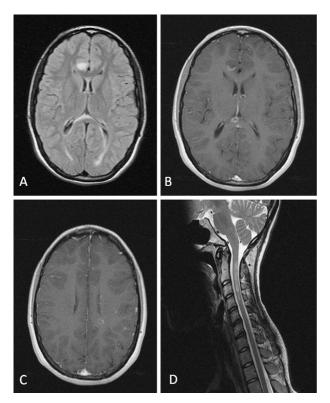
MRI images showing demyelinating lesions in the brain and spinal cord. (A) FLAIR image showing hyperintense lesions involving the frontal lobe and periventricular white matter and the splenium of the corpus callosum. (B-C) Postcontrast T1-weighted images showing lesion ring-enhancement. (D) T2-weighted image showing a longitudinally extensive hyperintense lesion involving C1-C2-C3-C4.
